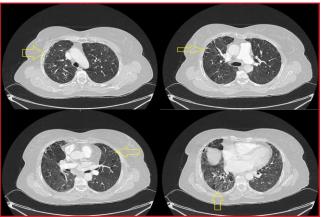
HRCT revealing peripherally located fibrotic density increases, traction bronchiectasis, ground glass densities, mosaic perfusion and air trapping areas, mostly in the central lung fields
